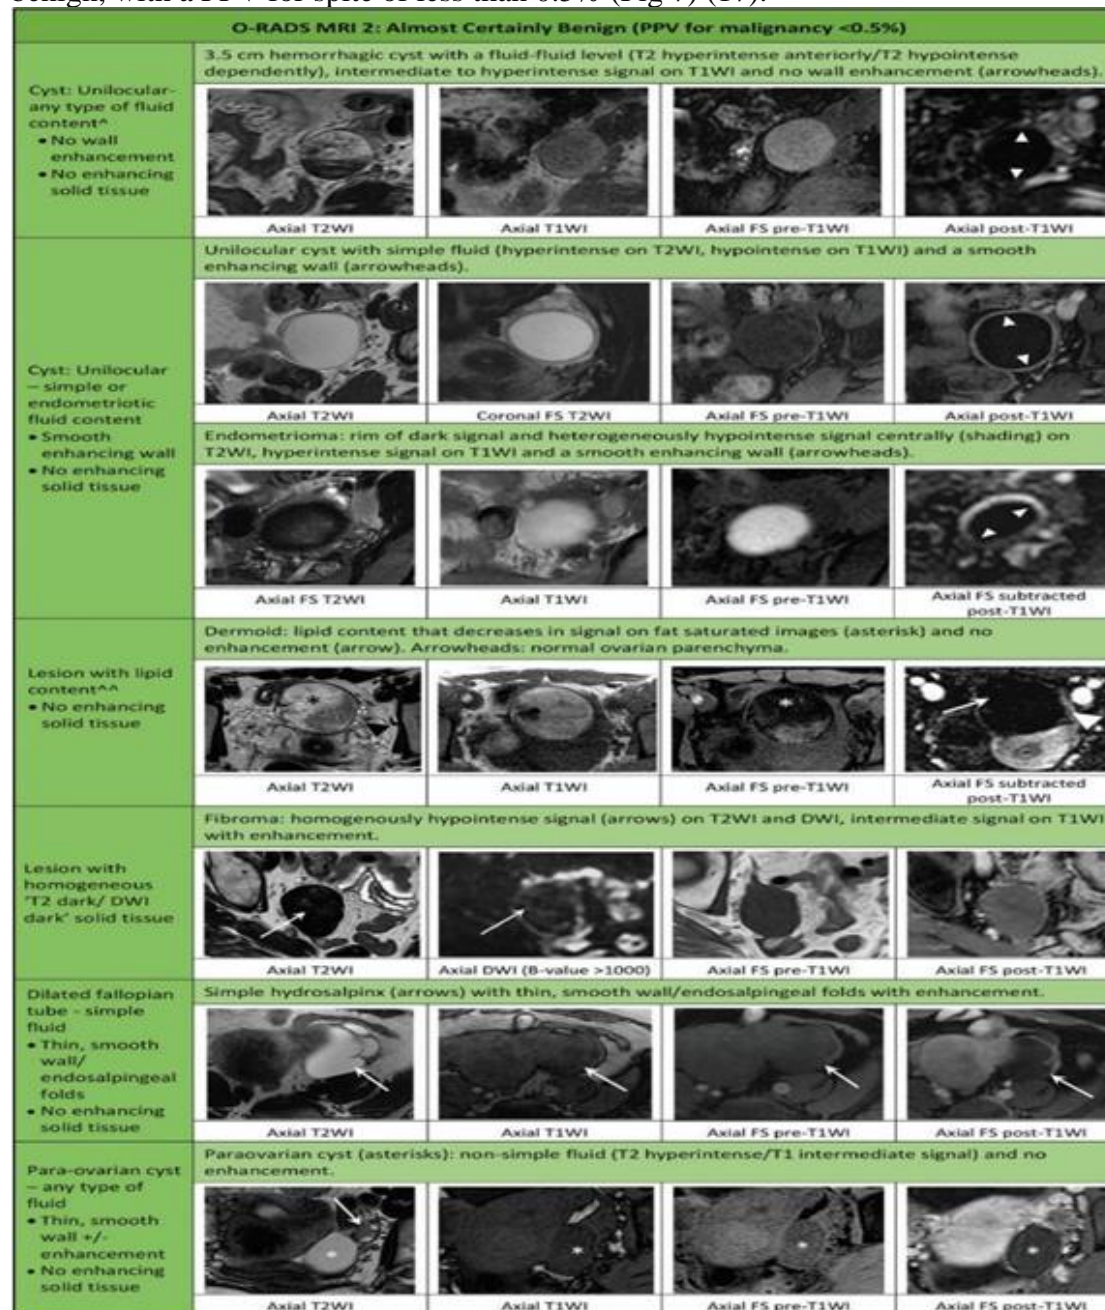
The image shows examples of Ovarian-Adnexal Reporting and Data System (O-RADS) MRI 2 risk score. [^] = Unilocular cysts with simple or hemorrhagic fluid 3 cm or smaller in a premenopausal woman would be classified as O-RADS MRI 1. ^{^^} = Minimal enhancement of Rokitansky nodule in lesion containing lipid does not change to O-RADS MRI 4. DWI = diffusion-weighted imaging, FS = fat saturated, PPV = positive predictive value, T1WI = T1-weighted imaging, T2WI = T2-weighted imaging. (18)
